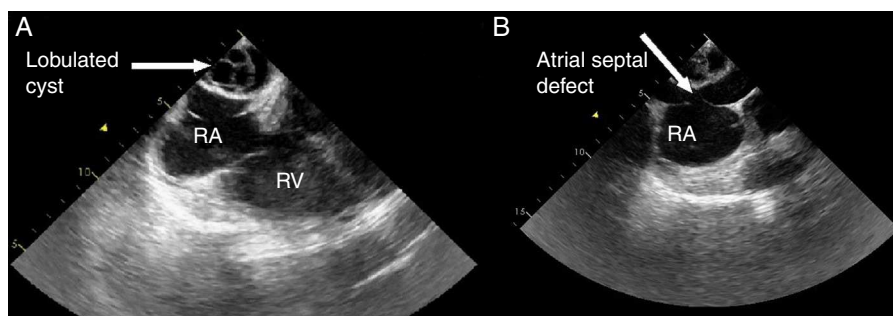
Transesophageal echocardiographic views showing (A) lobulated cyst and (B) atrial septal defect. RA: right atrium; RV: right ventricle.
